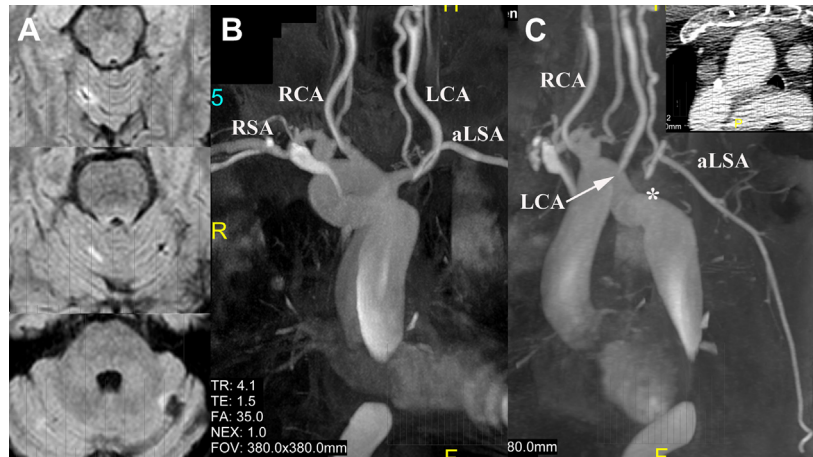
A, Magnetic resonance tomography scan of the brain with multiple infarctions in both cerebellar hemispheres, more pronounced on the left side. Furthermore, diffuse chronic ischemic alterations with atrophy of the brain stem could be demonstrated. In stark contrast, both brain hemispheres were completely free of any pathological findings. The findings described above, combined with the functional duplex-ultrasound examination, were compatible with a chronic vertebrobasilar ischemia. B and C, Magnetic resonance angiography of the thoracic aorta showing a circumflex right-sided aortic arch (anteroposterior [B] and left lateral view [C]). The first supra-aortic branch was the left common carotid artery (LCA) followed by the right common carotid artery (RCA) and the right subclavian artery (RSA; with a 17-mm aneurysmatic proximal segment). An aberrant left subclavian artery (aLSA), proximally occluded, originated from the proximal descending aorta (*). The aortic arch had a retroesophageal segment (*inset*) without a pronounced diverticulum of Kommerell.
